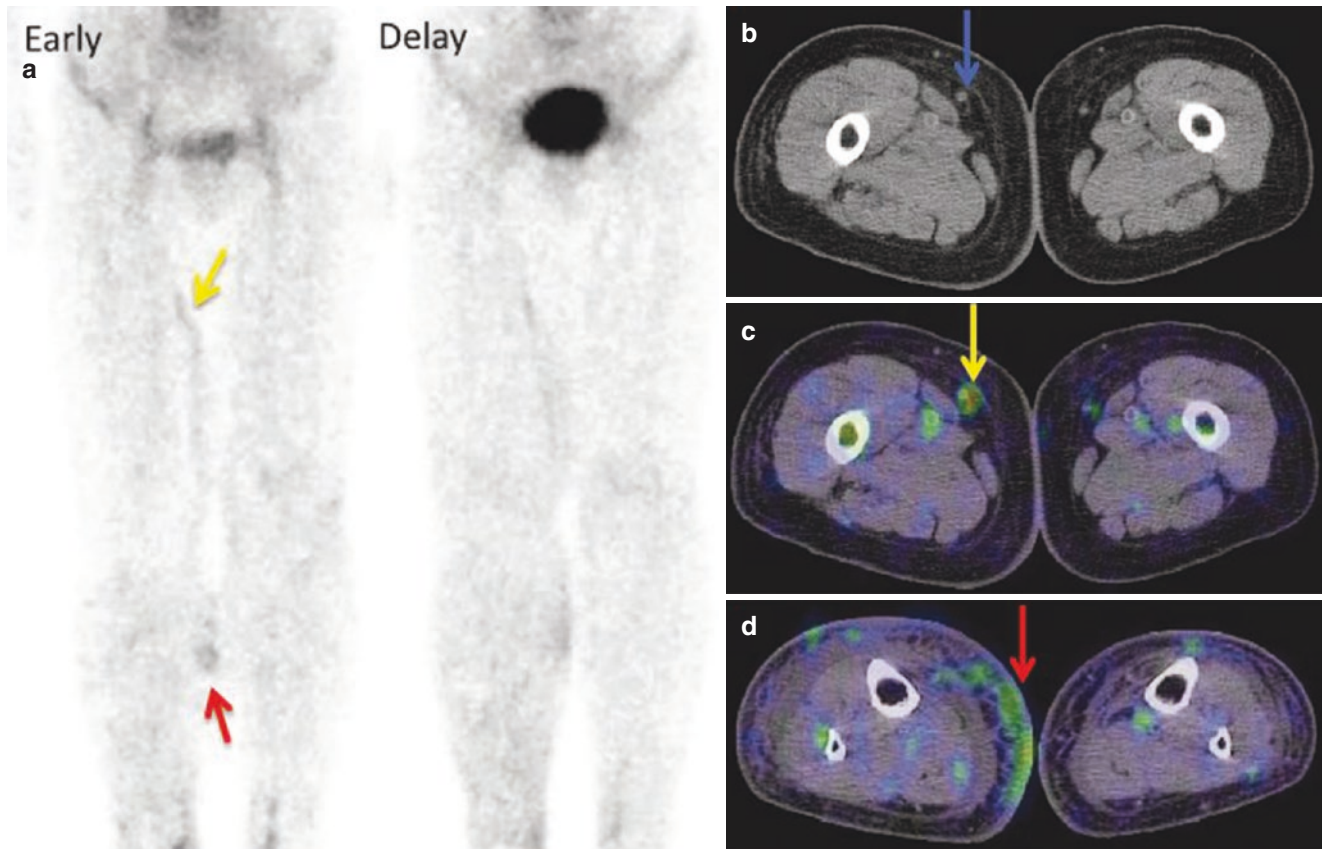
Lymphoscintigraphy with ^{99m}Tc -nanocol in an 81-year-old woman with bilateral lower limb lymphedema following surgery for uterine cervical cancer. The right lower limb, with more severe lymphedema, was considered as the affected side (ISL stage: II; LEL index: 338). (a) Both the early and delayed planar images show reduced/absent accumulation in inguinal lymph nodes. Although the planar images cannot discriminate the lymphatic vessel in the medial lower
